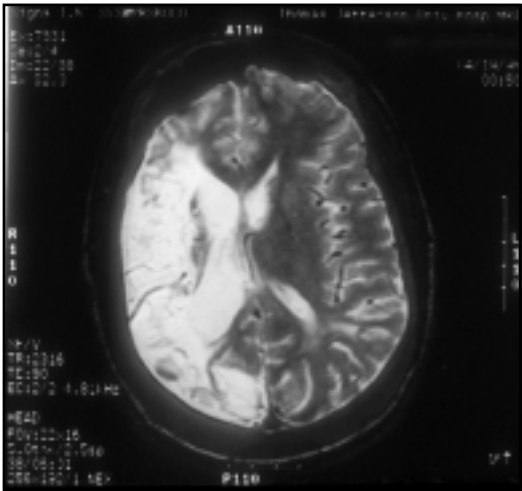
Magnetic resonance imaging (MRI) of the brain of a patient with sickle cell anaemia showing an infarct (white area) in the distribution of the middle cerebral artery with gliosis, encephalomalacia and midline shift.
